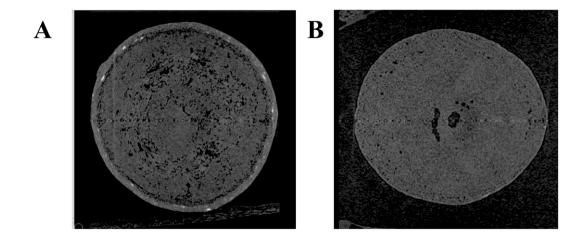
X-Ray CT images of granules found in sample B-040 collected in Cambodia in 2010. Note the presence of an apparently intact enteric-coated layer in (A) and the absence of an enteric-coated layer in (B)
